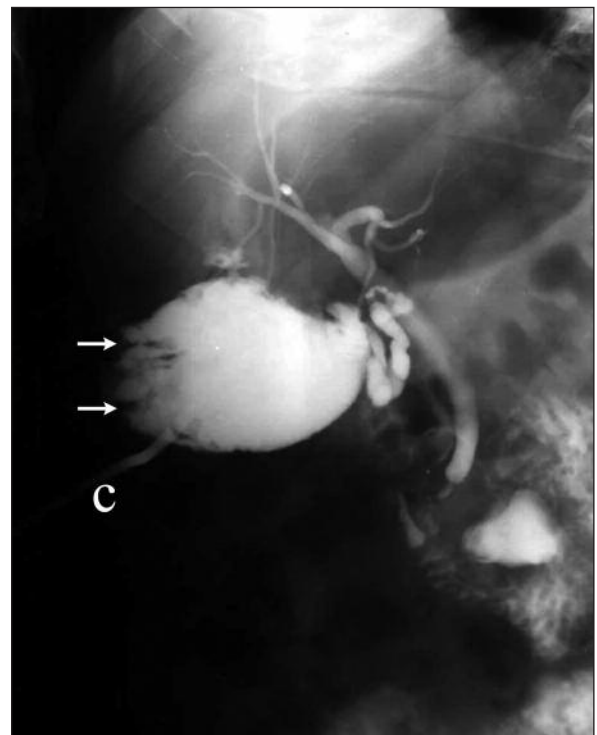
A 48 year-old male patient with pancreatic abscess after nephrectomy. a. Contrast-enhanced CT shows a left subphrenic abscess with air (arrows). b. This cavity was successfully drained with a 12F catheter (arrow) for 27 days. Catheter infection was seen and treated with antibiotic.
